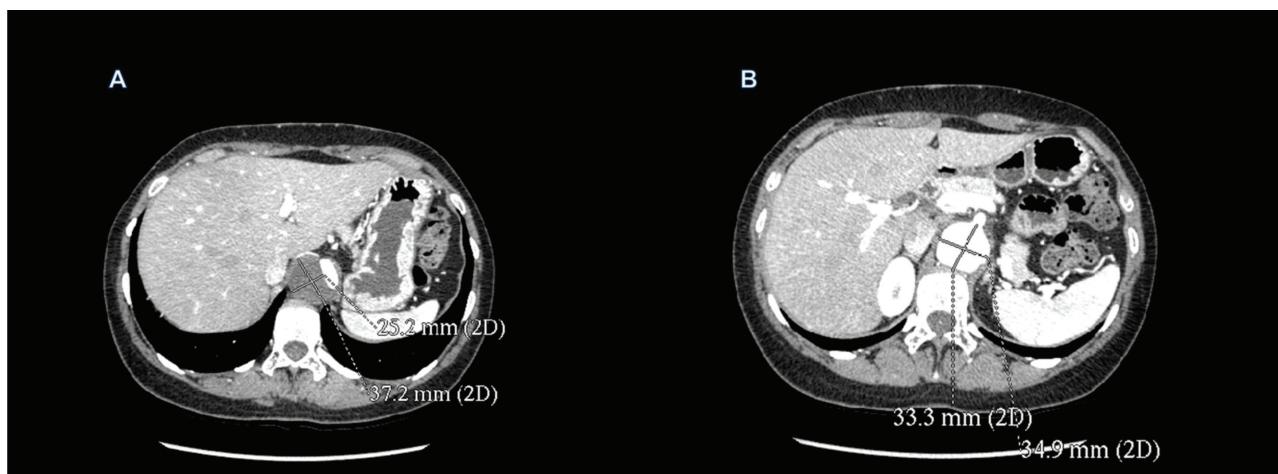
Two-year follow-up contrast enhanced abdominal computed tomography (axial views): A) dilatation and mural thrombosis of the false lumen of the dissected abdominal aorta with aneurismal dilatation of the false lumen. B) Distal communication between the true and false lumen.
